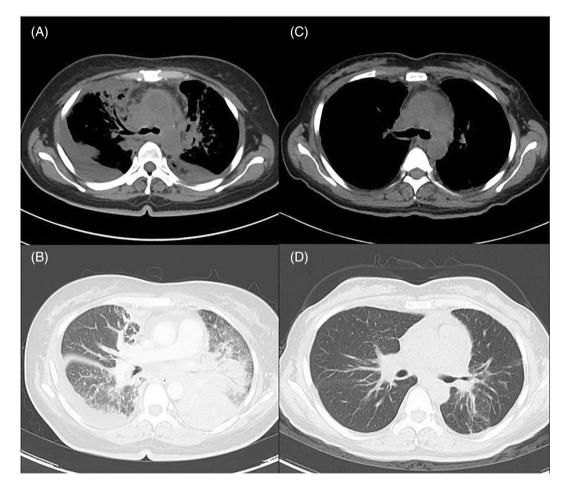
Chest CT scan images of the patient. (A and B) Pre-treatment CT scan showing extensive consolidations and lymphatic interstitial thickening in bilateral lungs with bilateral pleural effusion. (C and D) Post-treatment CT scan taken after 9 months of medications, demonstrating near complete resolution of the previously observed abnormalities.
